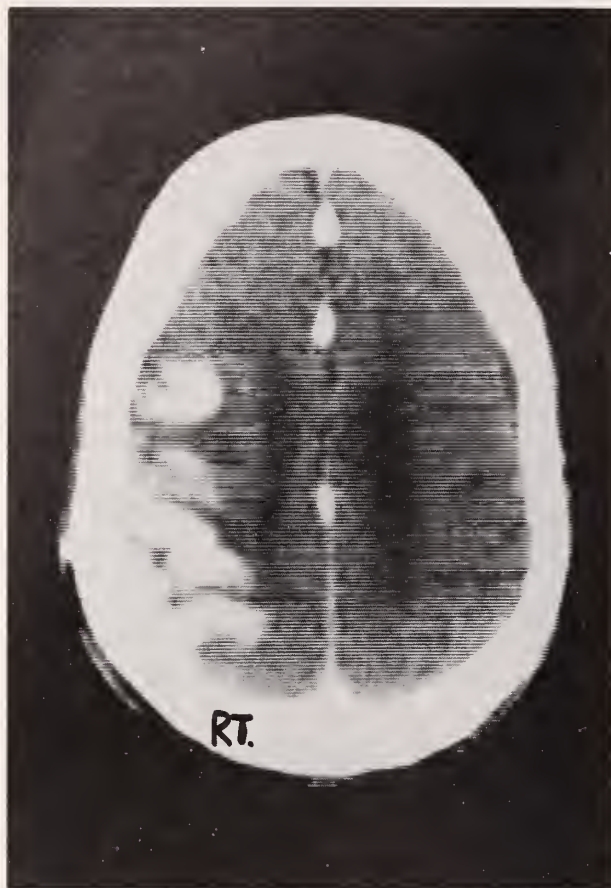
Case 2, post contrast CT scan.
